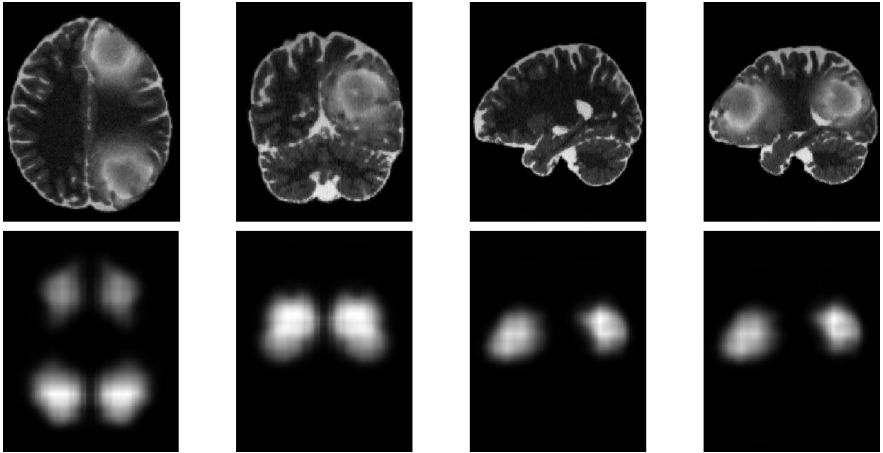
Example of asymmetry map. The top row shows the T2 slices with the highest asymmetry. The bottom row shows the asymmetry maps of the T2-weighted volume of the corresponding slices.
